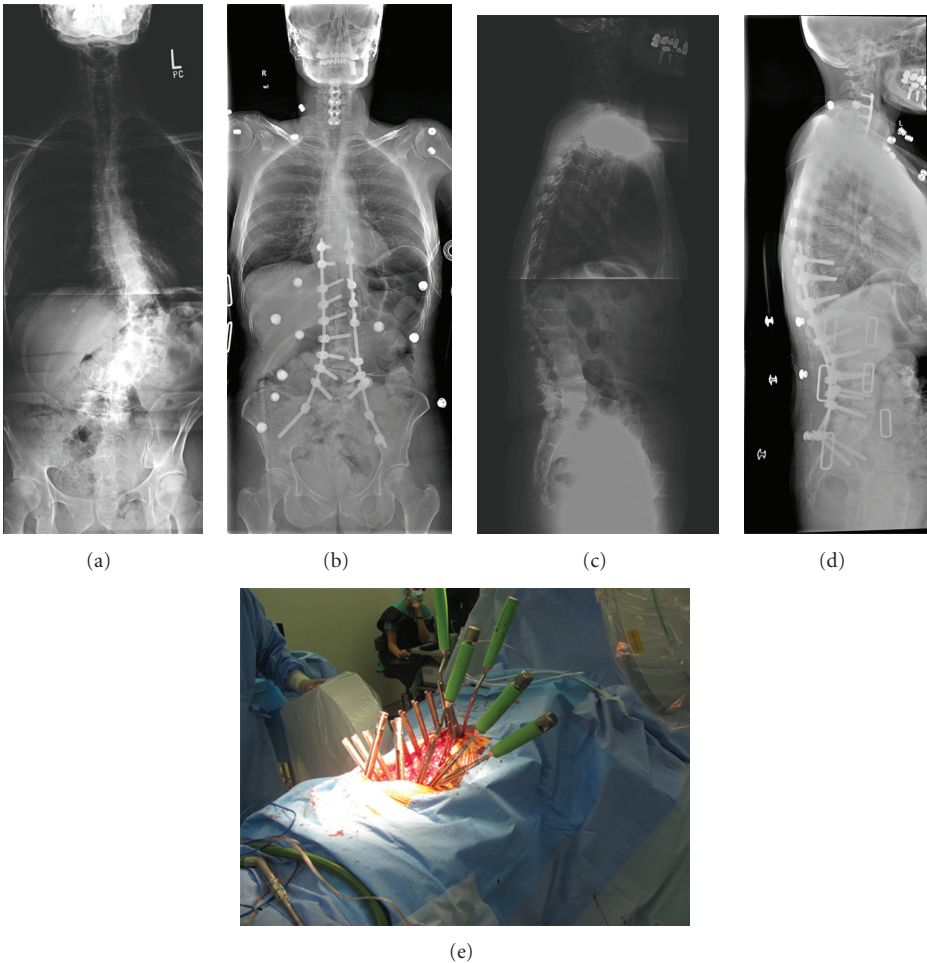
Case example showing a T9 to Iliac MIS fusion with interbody grafts at L2-S1. (a) and (b) Pre- and postoperative AP, and (c) and (d) Pre- and postoperative lateral 36" X-Ray images. (e) Intraoperative view.
